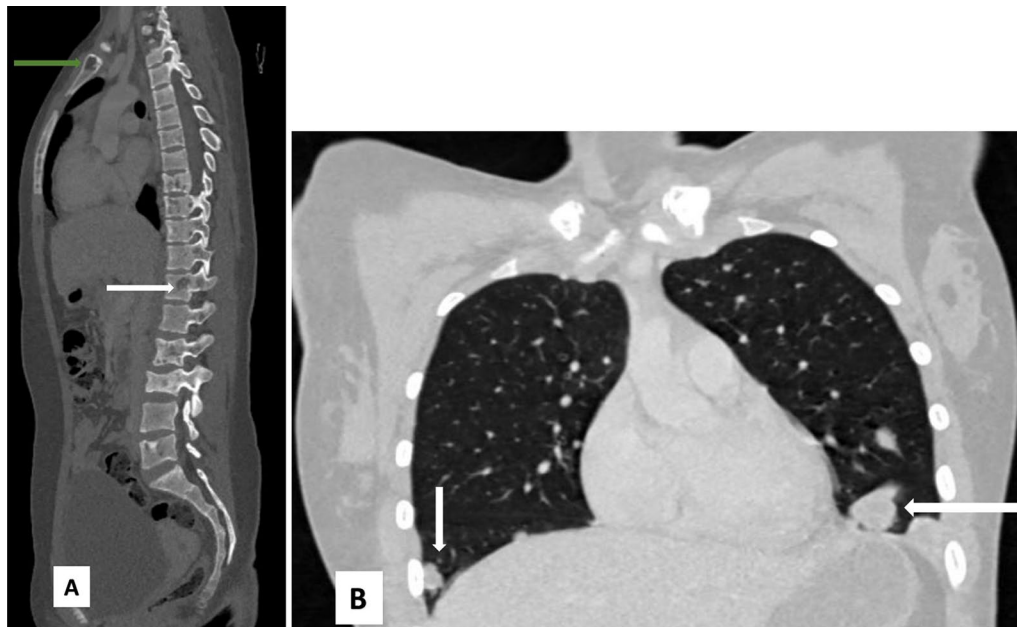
A Right parasagittal CT image in bone window show multiple lytic lesions in the thoraco-lumbar spine (white arrow). A well-defined lytic lesion is also seen in the manubrium sterni (green arrow). B Coronal CT Reformat Image in lung window shows multiple round metastatic deposits (white arrows) in the bilateral basal lung segments
